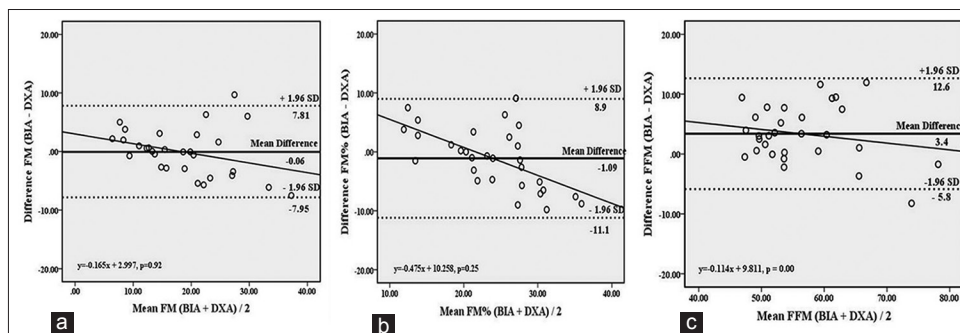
(a-c) Bland–Altman's plot showing 95% limits of agreement with mean difference between dual X-ray absorptiometry and bioelectric impedance analysis
